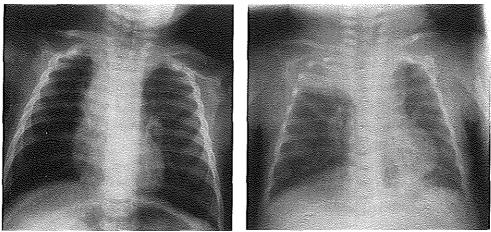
Chest radiographs of patients with respiratory syncytial virus infections showing hyperinflation (left) and atelectasis (right) (courtesy of F. Jansen MD, department of Radiology, Catharina Hospital Eindhoven).
